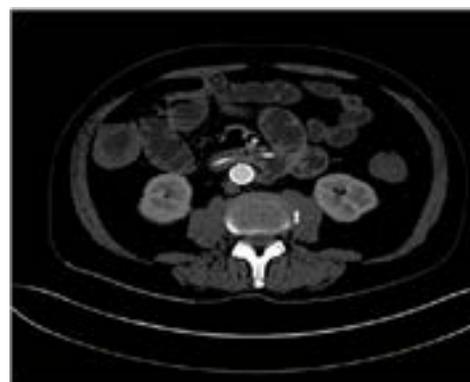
Post-operative CT shows the efficacy of the endoprosthesis
